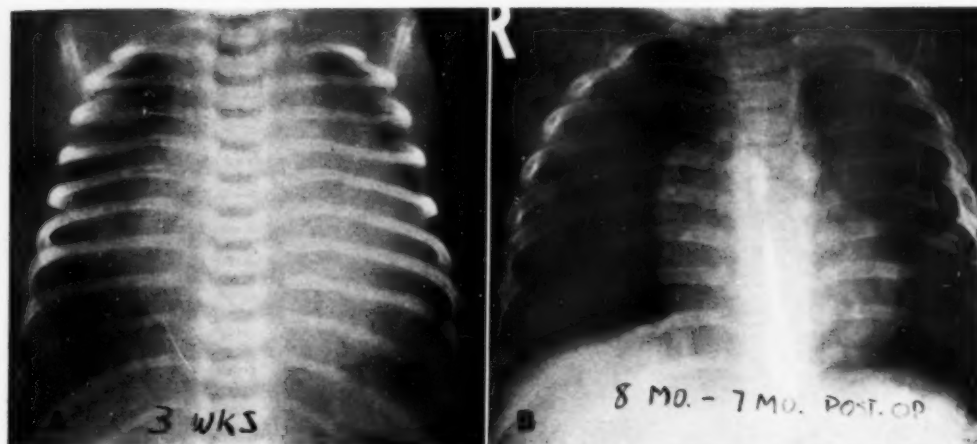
Coarctation of the aorta. In this 3-week-old boy congestive heart failure developed shortly after birth. Physical examination showed cardiac enlargement, a loud systolic murmur over the entire precordium, and absence of femoral pulses. Roentgenologic studies demonstrated gross cardiac enlargement and congested lung fields, and retrograde aortography confirmed the diagnosis of coarctation of the aorta. At the age of four months, the coarcted segment was excised and an end-to-end anastomosis performed, with excellent postoperative results.
